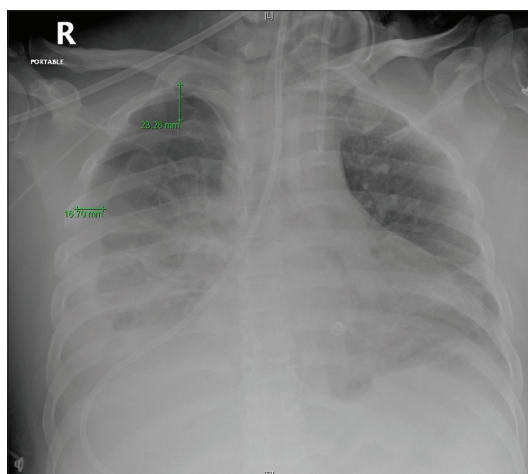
This chest X-ray demonstrates misplacement of the nasogastric tube into the right lung with right lower zone consolidation, pleural effusion, and pneumothorax
